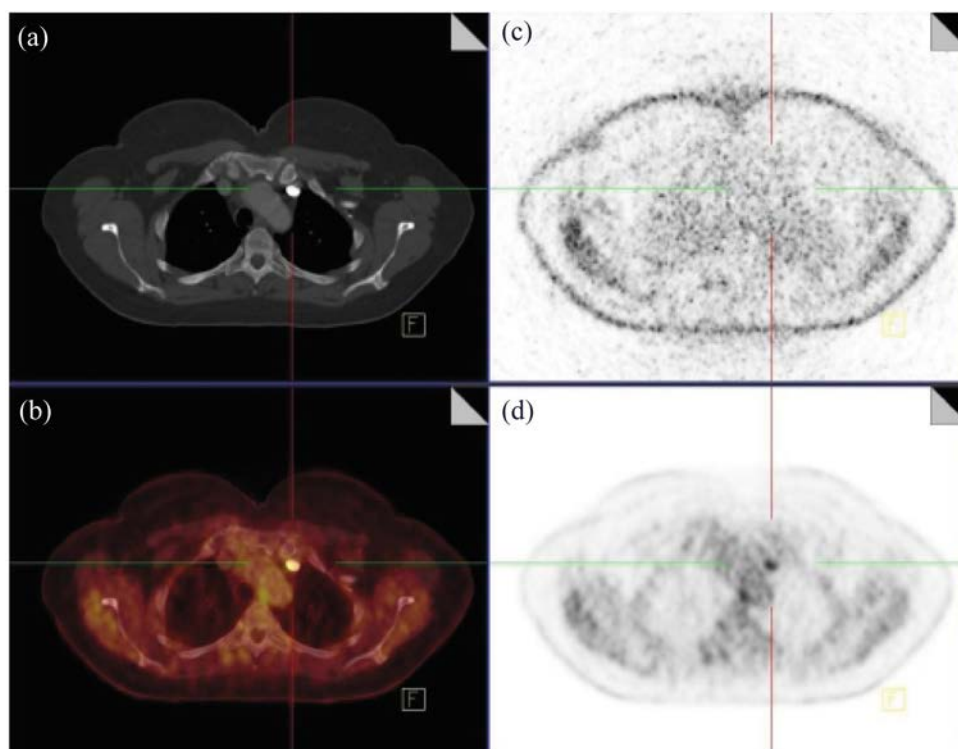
Transaxial images of a whole body FDG-PET/CT study with intravenous contrast. (a) CT image shown in bone window; (b) fused AC-PET and CT; (c) uncorrected PET; (d) AC-PET demonstrating hot spot artefacts corresponding to intravenous contrast accumulation. AC: attenuation corrected.
